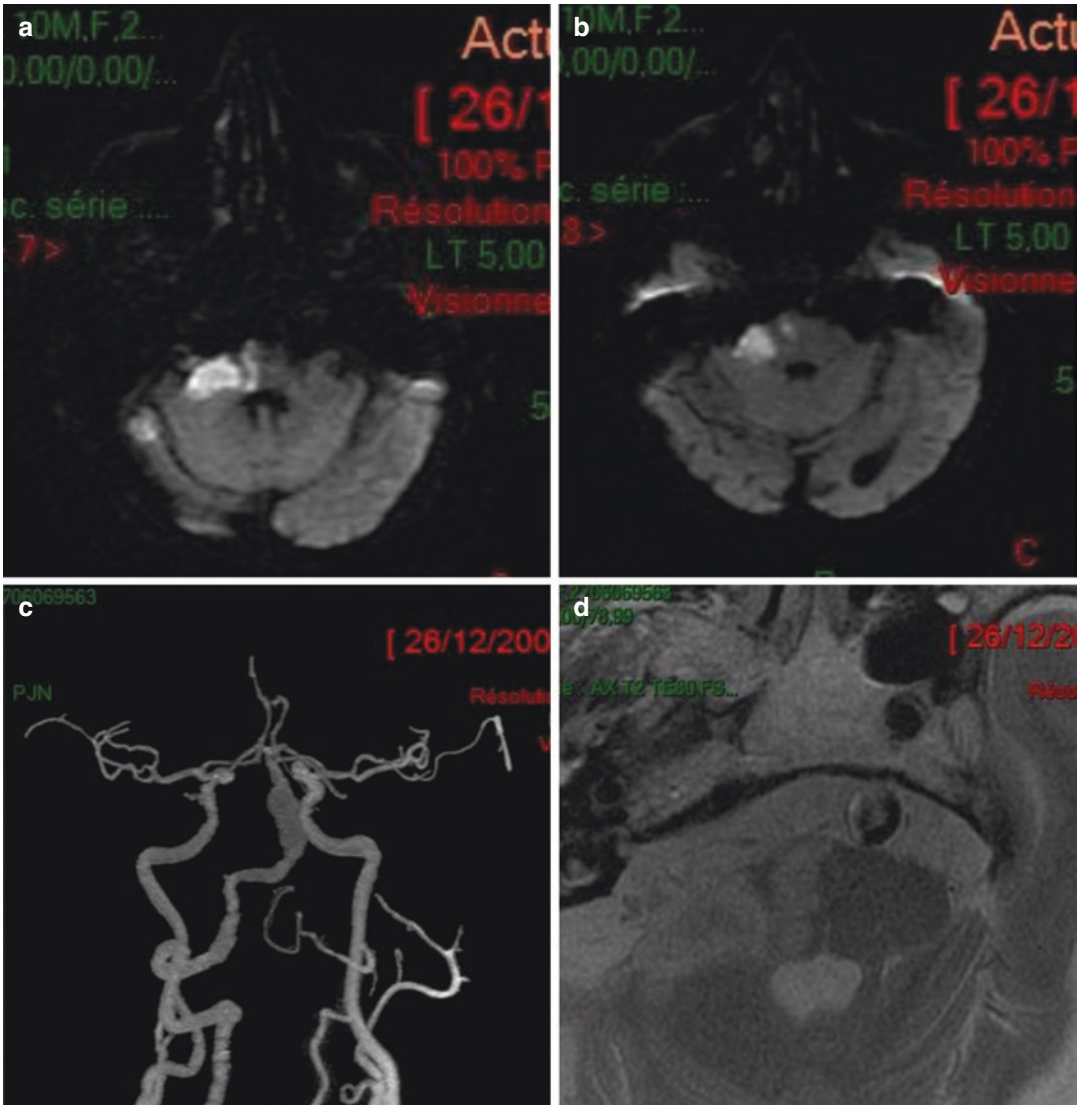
An 85-year-old patient with AICA infarct (A, B) due to a dolichoectatic basilar artery (C). High-resolution MRI (D) showing a thrombus inside the basilar artery
